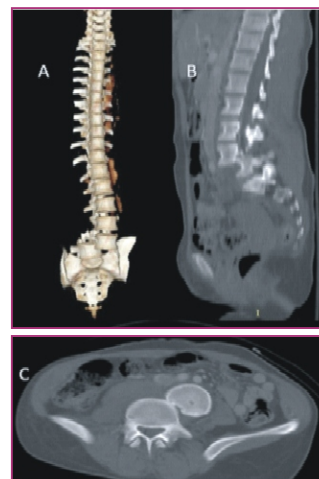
(A, B, C): 3D CT scan, mid sagittal and axial sections showing Meyerding grade V dislocation at L4-L5.
